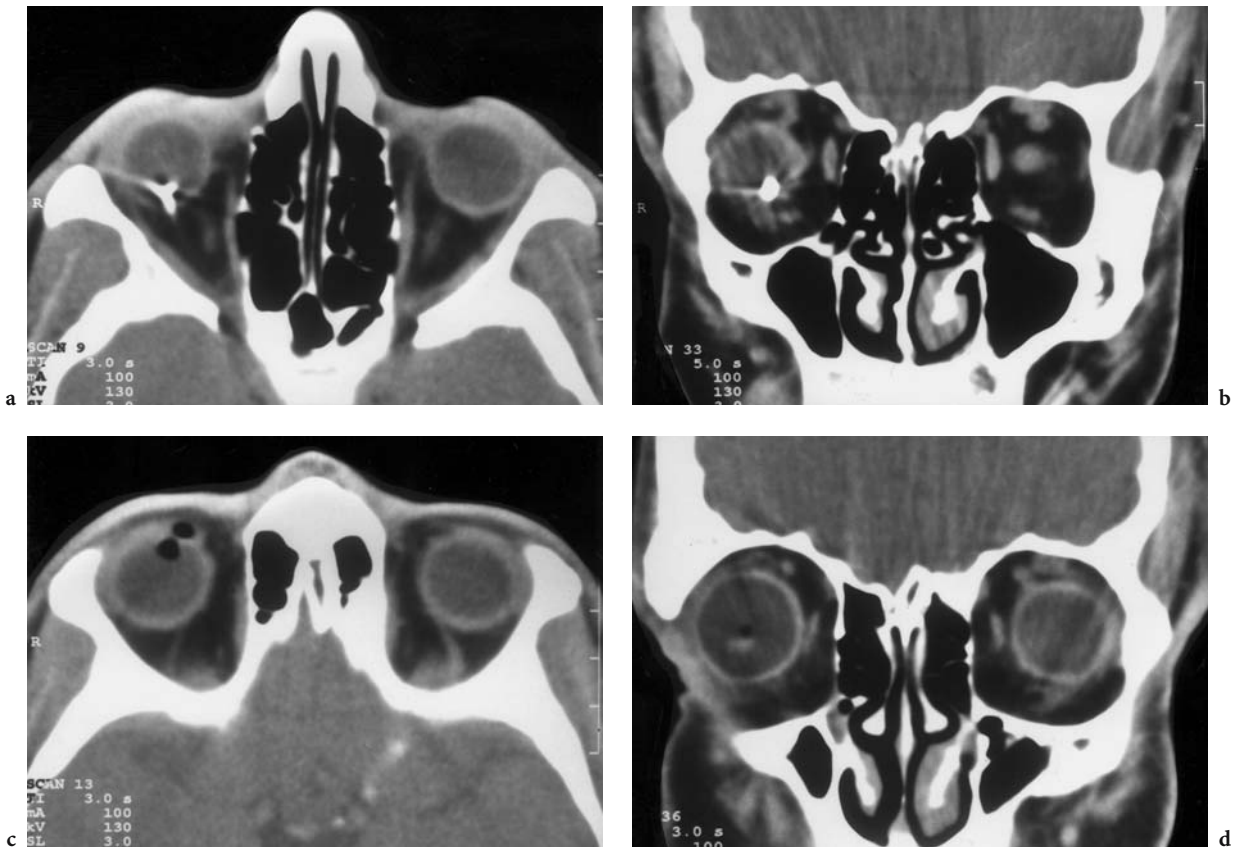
A 22-year-old man with vision loss of the right eye after a hammer-chisel injury. Diagnosis: keratorhexis, lens dislocation, and iris injury due to foreign-body injury. CT: a Axial view of the inferior orbit with definition of the metallic foreign body in the posterior region of the right globe. b Corresponding coronal view. c Axial view of the superior orbit: air inclusion defines the location of the entrance of the foreign body. d Corresponding coronal view depicts an additional air inclusion superior to a hyperdense formation, confirmed on vitrectomy as the lens
